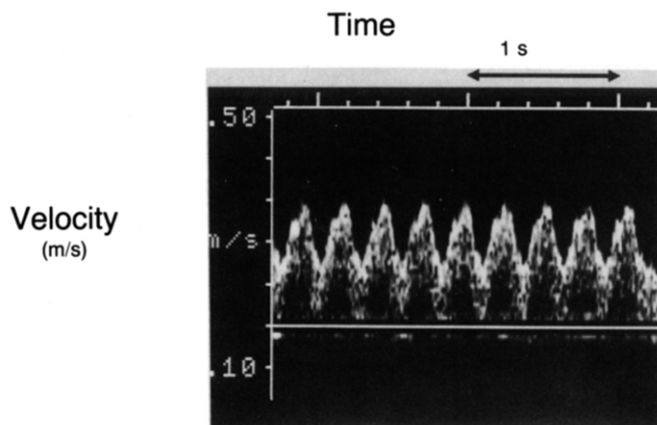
Doppler signal derived from the pulsatile pumping of the fluid while the tubing remains stationary.
